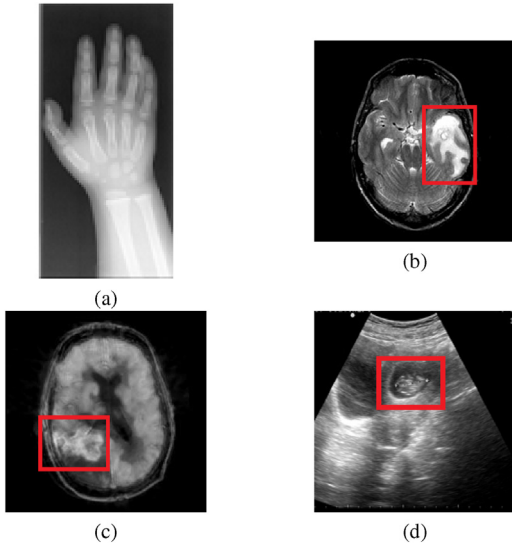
Original medical images. (a) CT, (b) MRI, (c) PET, (d) Ultrasound.
